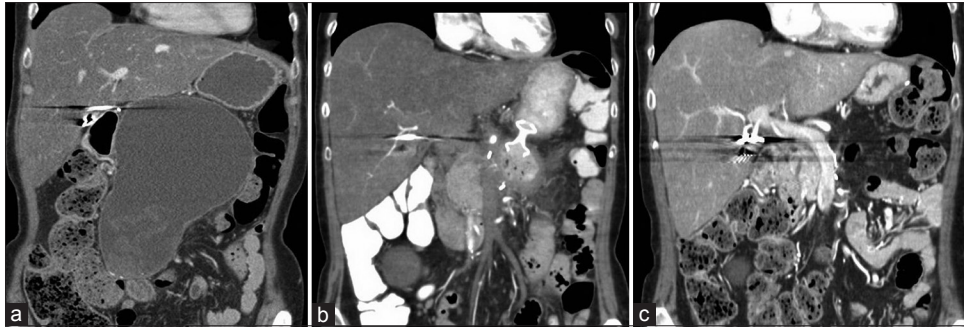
Computed tomography images obtained before and after drainage. (a) Large cyst before cystogastrostomy. (b) Stent is still in place, and the cyst size is decreased. (c) Stent was removed after cyst resolution
